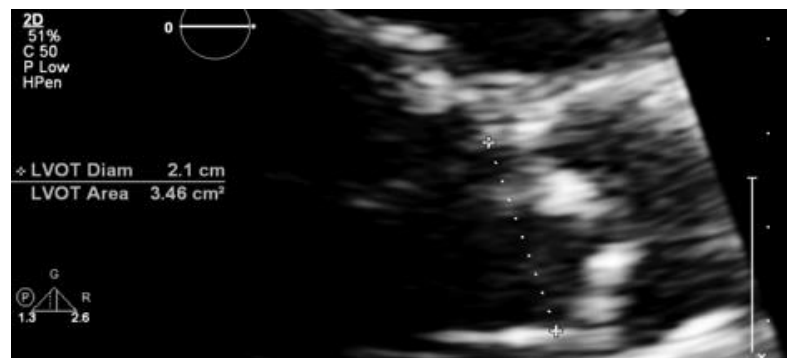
An example of LVOT diameter measurement (dashed line) on a zoomed-in parasternal long-axis view of the LVOT.
